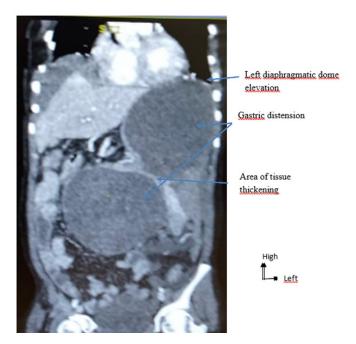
Abdominal CT scan with coronal reconstruction of the gastric volvulus in our patient showing elevation of the left diaphragmatic dome, gastric distension and the gastric plication area (Image from the surgery department of the Ziguinchor Peace Hospital).
